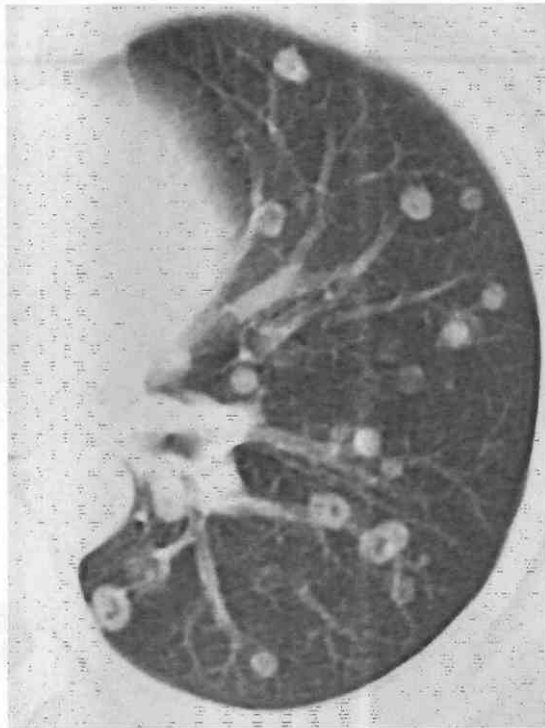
Bronchioloalveolar cell carcinoma (BAC) manifesting as multiple pulmonary nodules. CT shows small, well-marginated pulmonary nodules with central areas of cavitation (the “Cheerio” sign of BAC).
